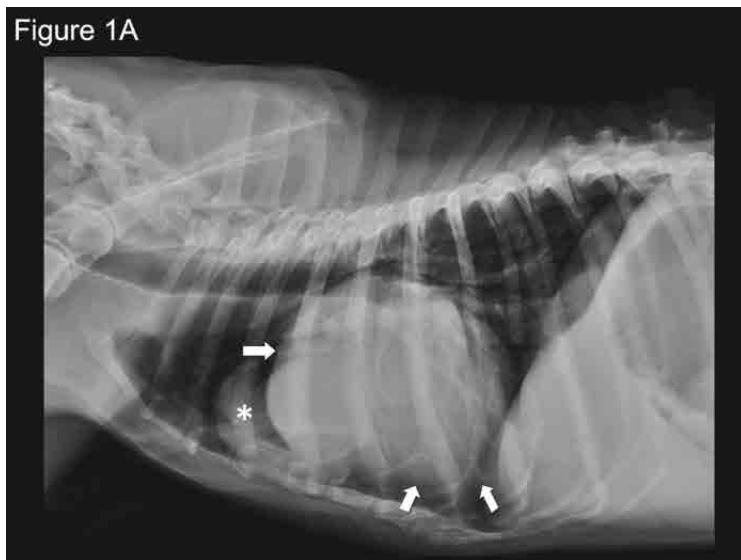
(1A and 1B): Right lateral (1A) and ventrodorsal (1B) radiographs of the thorax showing the presence of a voluminous soft tissue mass (asterisk) silhouetting with the enlarged cardiac shadow (arrows). The cardiac silhouette demonstrates an upward rotation on the lateral view and a contralateral shift on the ventrodorsal view.
